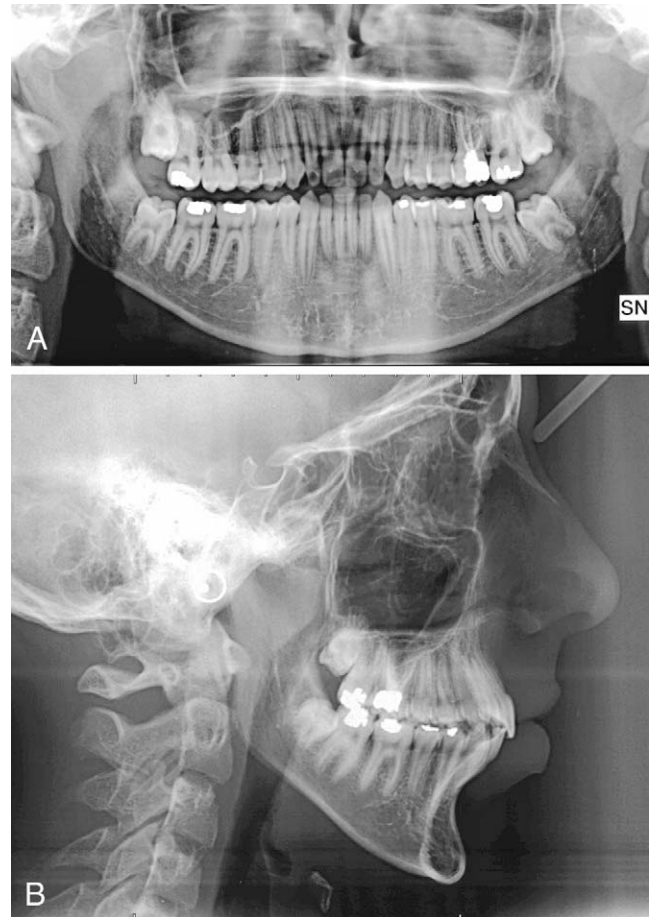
Long-term (29 months posttreatment) panoramic and cephalometric radiographs.
